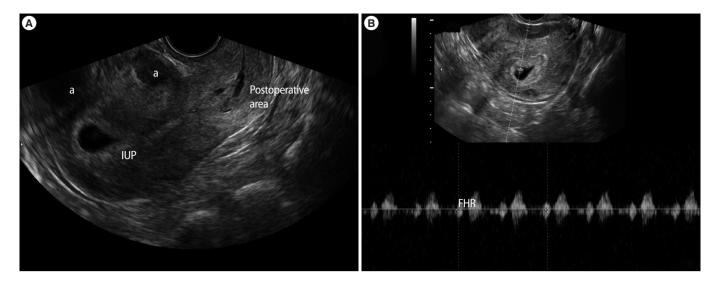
Postoperative vaginal ultrasonography on the seventh postoperative day (6 weeks+1 days of gestation). (A) A hypervascular echogenic change was shown in the cervical area, whereas the intrauterine pregnancy continued. (B) The heartbeat was positive and biometrics were consistent with the gestational age. IUP, intrauterine pregnancy; FHR, fetal heart rate. ^aUterine fibroid.
